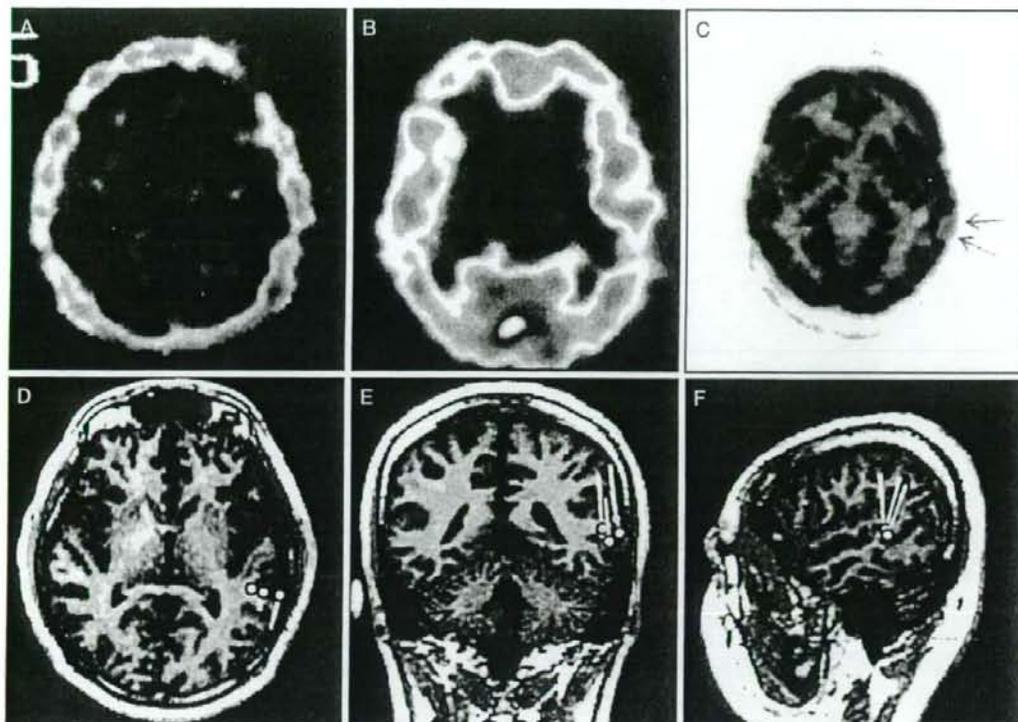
SPECT, PET and MEG
